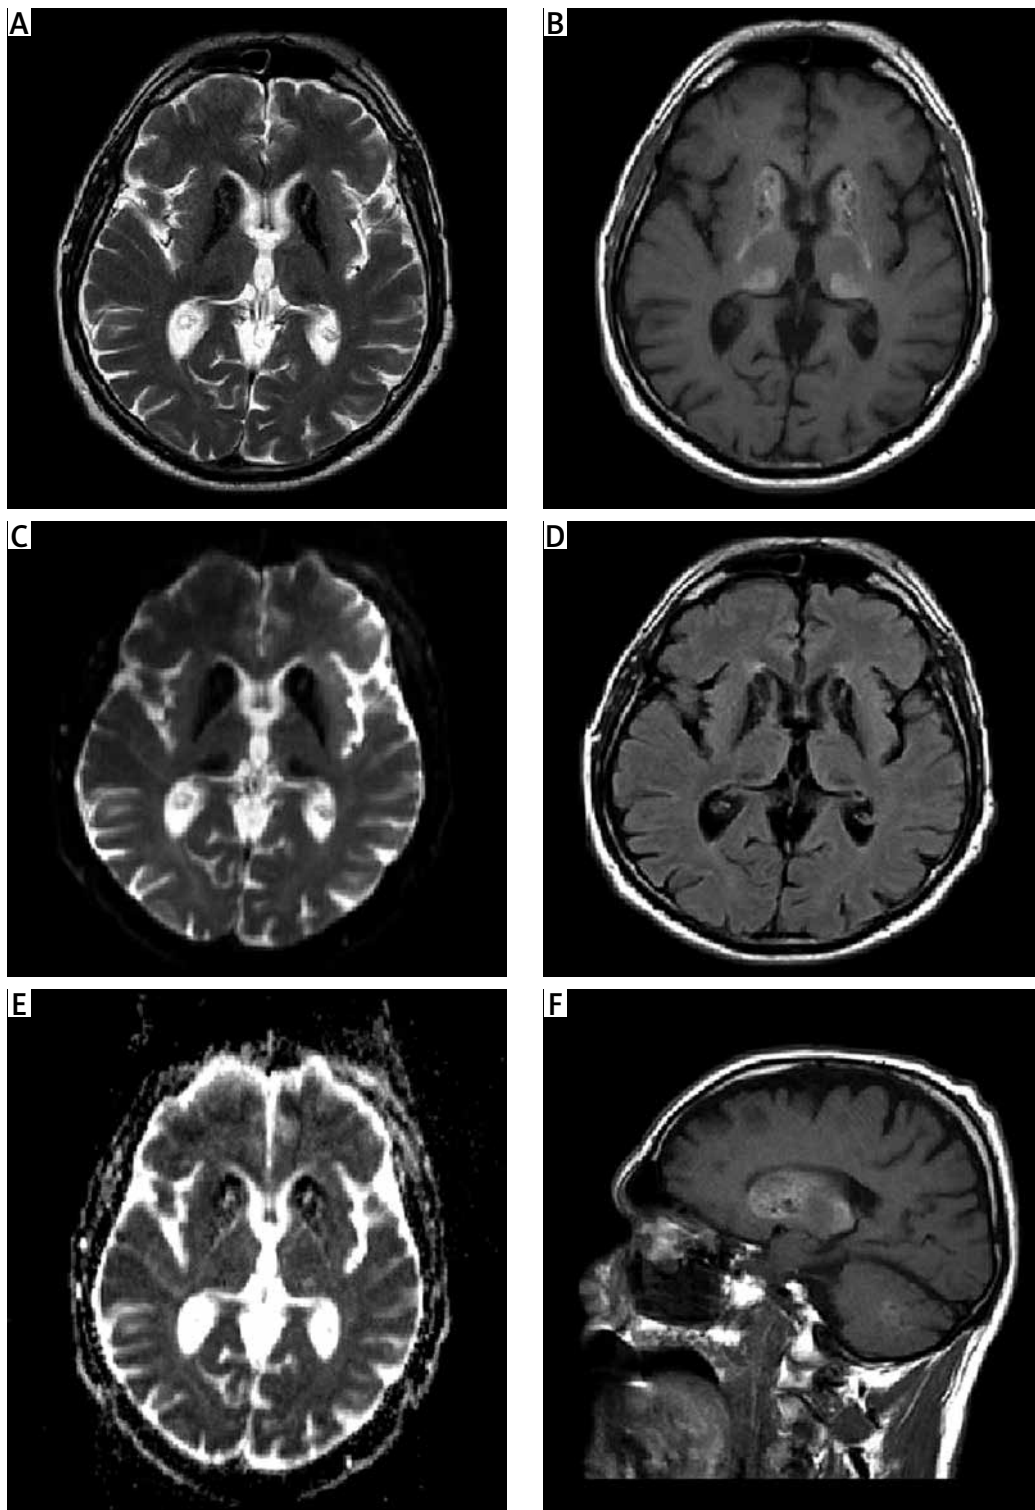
Magnetic resonance imaging (MRI) findings in patient 1: (A, D) T1 and (B) T2-weighted image, (C) diffusion weighted imaging (DWI) and (E) apparent diffusion coefficient (ADC) map, (F) fluid-attenuated inversion-recovery (FLAIR) image. Calcified areas show high- or low-intensity signals on MRI T1-weighted images. On T2-weighted image calcification is depicted as low-intensity signals. Multiple small patchy hypersignals on FLAIR sequence. Dark spots are noted on both the DWI and the corresponding ADC map.
